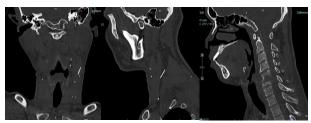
CT cervical spine images
